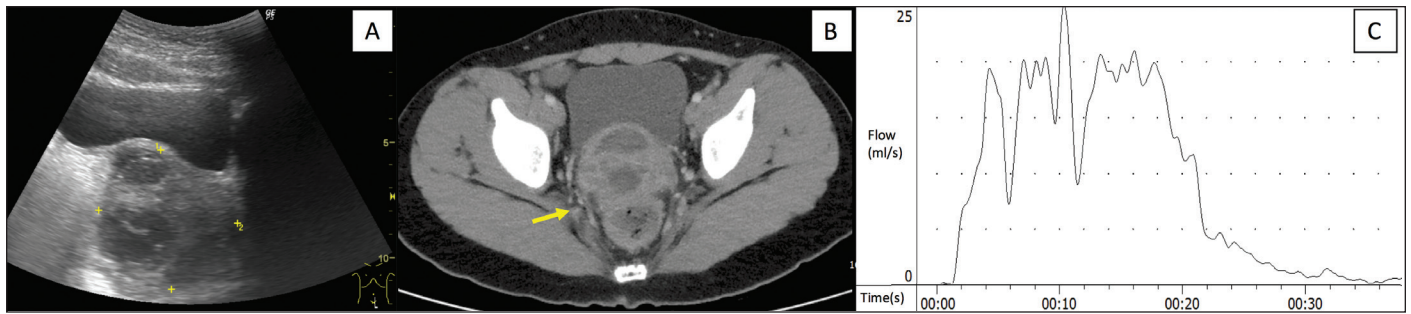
(A) Abdominal sonography revealed a heterogeneous septated mass. (B) Contrast-enhanced computed tomography scan of the abdomen and pelvis revealed prostatic abscess with multiple loculations (arrow). (C) Uroflow revealed staccato pattern.
